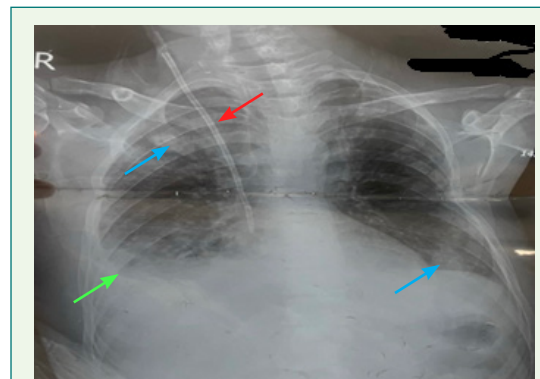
Chest X-ray of the patient, PA view shows an intravenous catheter (central Line) on the right side, red arrow. The tip of the catheter is in the right heart chambers, with a right-sided pleural effusion (meniscus sign) (green arrow). Although the film was not taken in full inspiration, we can clearly see at least two opacities (blue arrows): the first in the upper zone of the right lung and the second in the pleural-based lower zone of the left lung.
